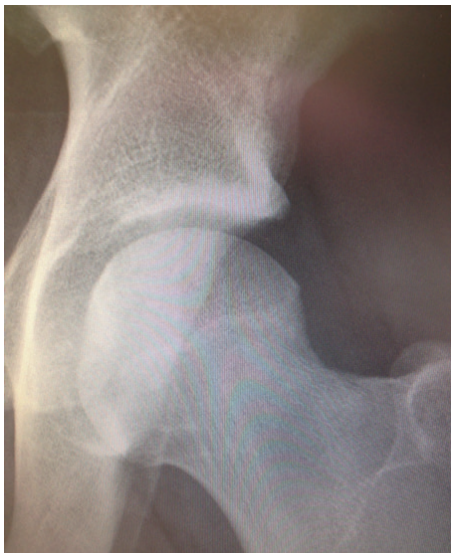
b. *postoperative image after resection of pincer deformity in figure 32 a above. Note that as this is only a left hip AP radiograph, some of the disappearance of the crossover sign could be due to different pelvic rotation.*
